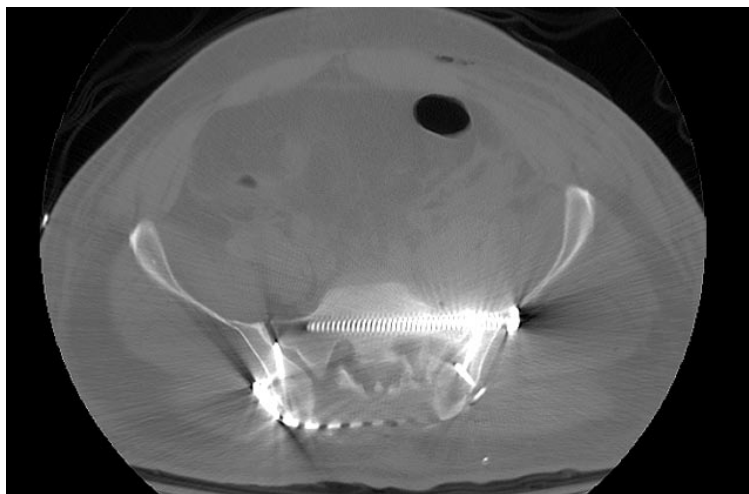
The pelvic CT scan after surgery demonstrates the reduction quality and implant safety.
